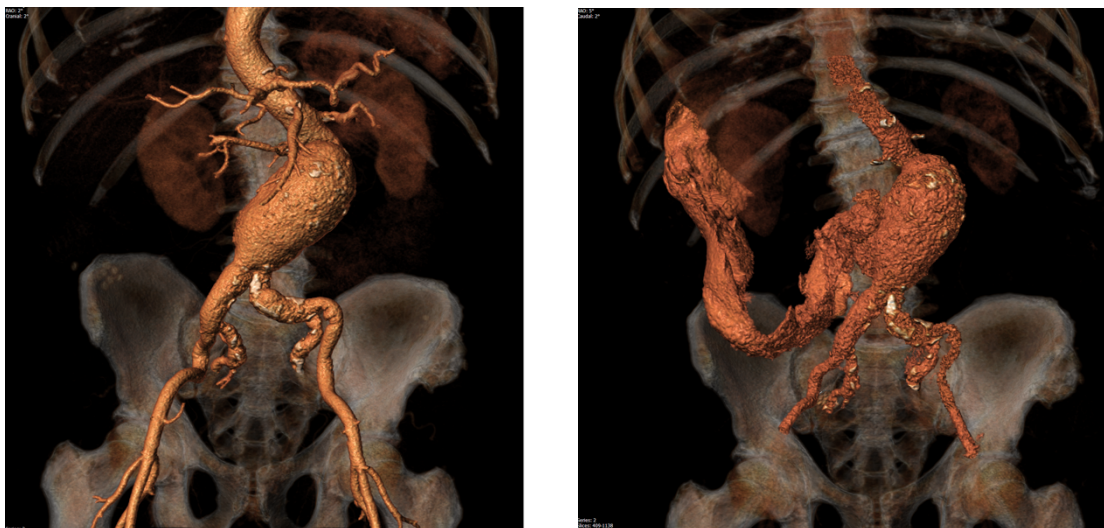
Three-dimensional CT angio reconstructions of intact abdominal aortic aneurysm (left), and of the same aneurysm after rupture (right).
